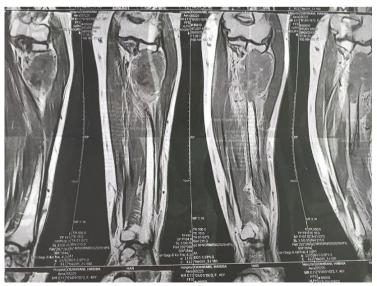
brown tumor appearance of proximal right radius on MRI
